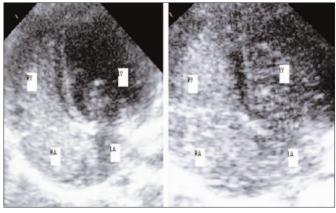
Bubble contrast echocardiogram demonstrating contrast filling the right cardiac chamber initially followed by filling of left sided cardiac chamber 6 cardiac cycles later.
